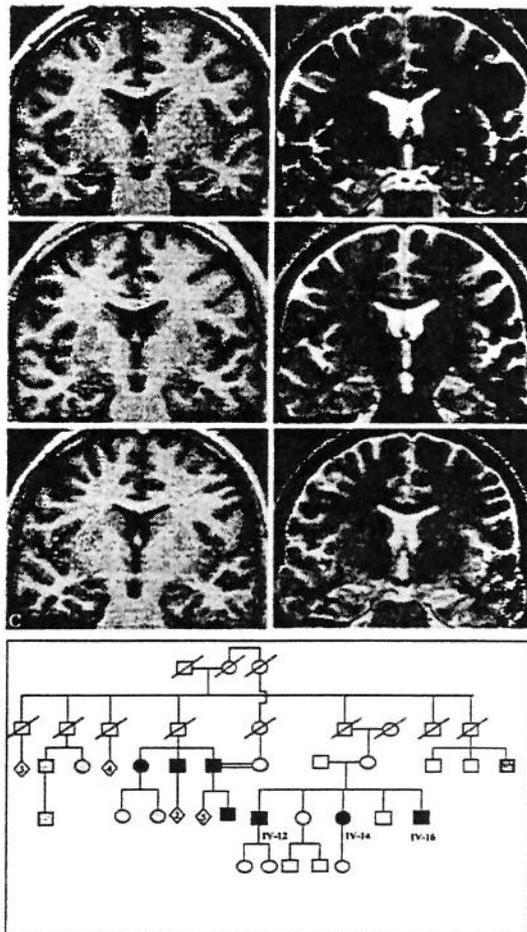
Coronal T1 inversion recovery and T2-weighted images of three siblings from one family with nine other affected and possibly affected individuals, showing unilateral hippocampal atrophy with hyperintense T2 signal and abnormal internal structure. (A) Patient IV-12 is a 37-year-old man who had onset of complex partial seizures at 2 years of age and has been seizure free and off medication since age 10 years. (B) Patient IV-14 is a 31-year-old woman who has had complex partial seizures since age 14 years, refractory to adequate antiepileptic medication. (C) Patient IV-16 is a 28-year-old man who has had well-controlled seizures since age 2 years. Open squares and circles = unaffected; solid squares and circles = affected; circles and squares with slash = deceased.
